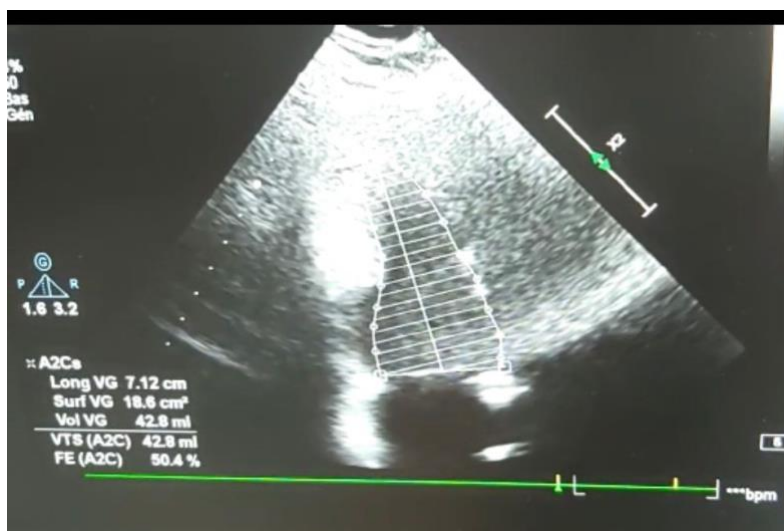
Transthoracic echocardiography at admission
